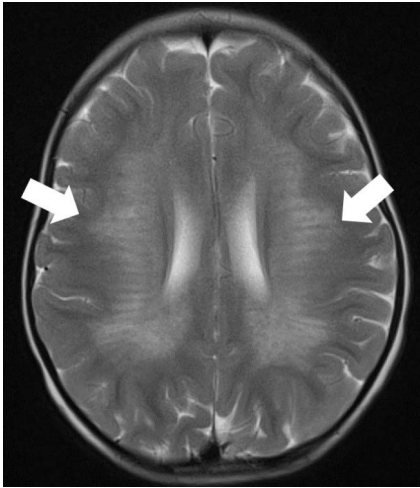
A 5-year-old child with Krabbe disease. (a) A T2-weighted axial image showing hyperintensity of the periventricular and deep white matter with a tigroid sign (white arrows), which refers to multiple linear structures with low signal intensity within the demyelinated white matter. (b) This patient also shows T2-hyperintensity extending to the brainstem (black arrows). (c) T2-hyperintensity in the splenium of the corpus callosum (white arrowhead) is also noted, not involving the genu (black arrowhead). (d) A T1-weighted axial image showing volume decrease in bilateral thalami (short white arrows).
